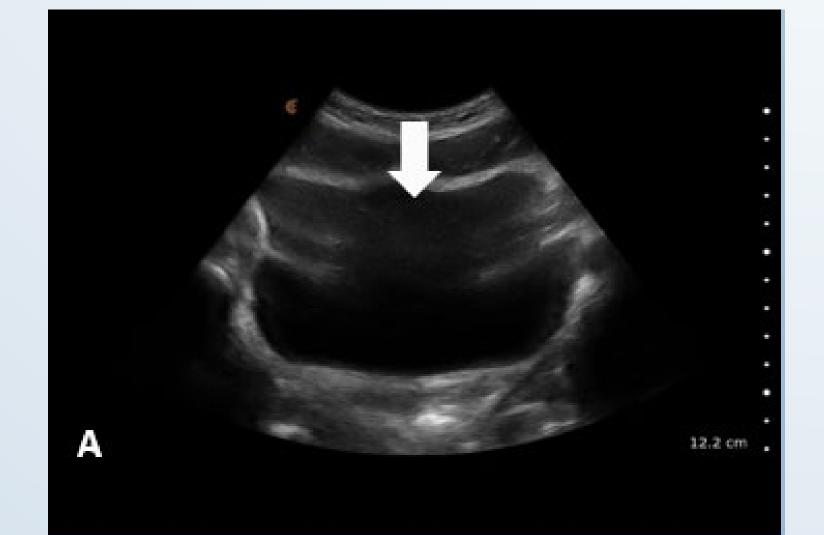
Transabdominal Ultrasound Images Caudal displacement of the bladder base during: A. The ASLR test B. The ASLR test wearing a lumbopelvic stability belt shown below
